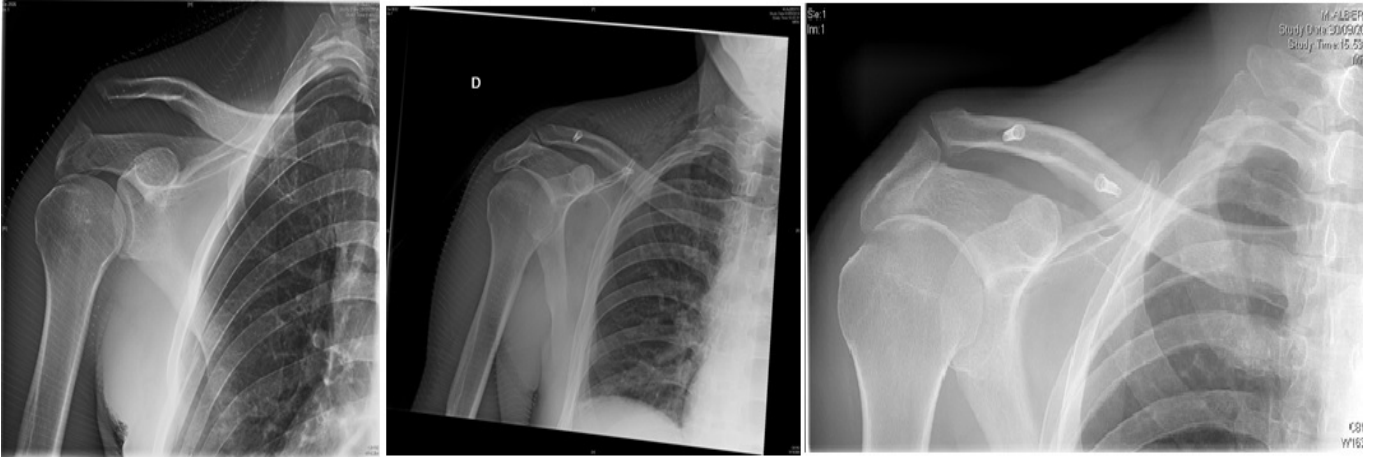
Radiography of acromion clavicular dislocation Rockwood type V. A) Initial injury; B) follow-up performed at three months after surgery; C) final follow-up performed at 12 months after surgery.
